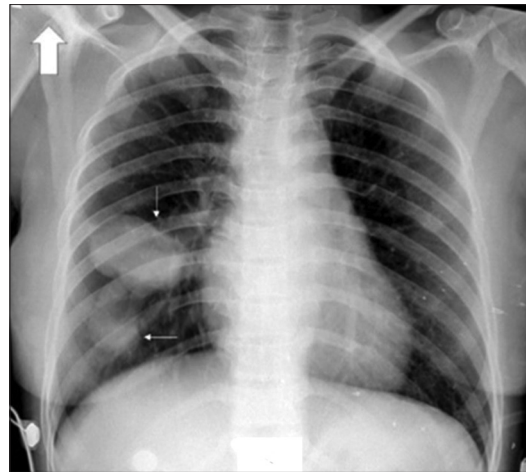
X-ray chest PA view- Bilobed opacity right mid & lower zone
